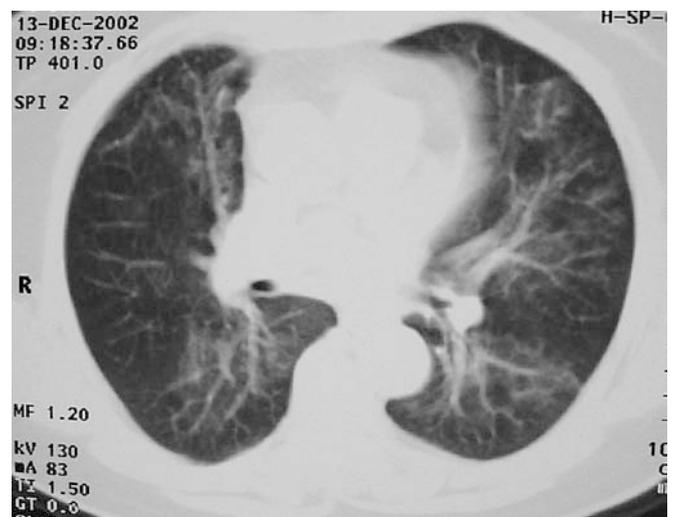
On control thorax CT scan, which was performed 45 days after the second examination, previously described alveolar infiltrates are seen to regress significantly, but focal ground glass densities are still present
